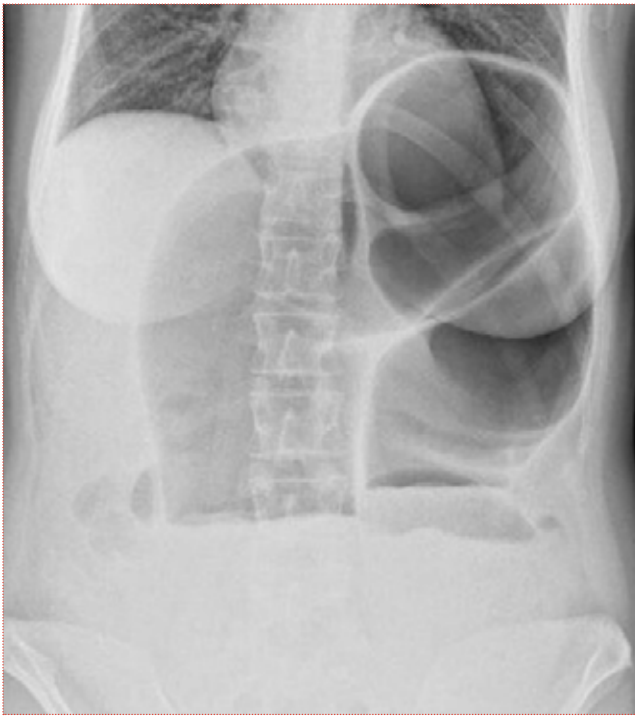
Abdominal X-ray showing a distended loop of sigmoid colon, resembling a “coffee bean”.
